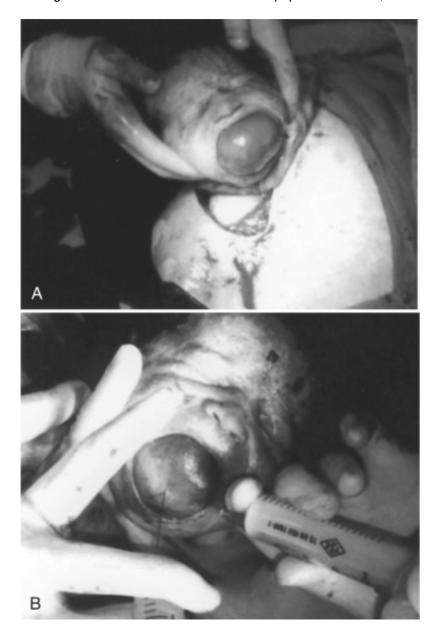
A, The cyst filled the mouth completely at birth. B, Clear fluid was aspirated to open the airway before the cord was clamped. (Reprinted with permission from Onderoglu L, Saygan-Karamursel B, Deren O, et al: Prenatal diagnosis of ranula at 21 weeks of gestation. Ultrasound Obstet Gynecol 22:399-401, 2003.)
